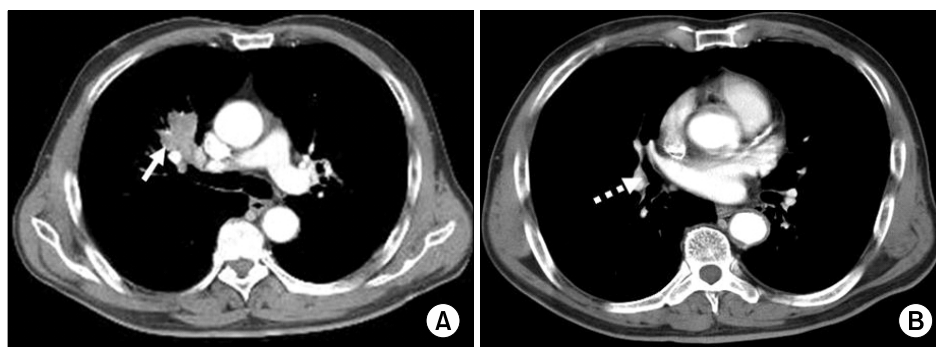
Preoperative images of CT showed (A) about 3.7×2.7 cm sized heterogenous enhancing low density mass with total obstruction of anterior segmental bronchus of right upper lung (solid arrow), (B) proximal portion of right middle and lower bronchus is unremarkable (dashed arrow).
